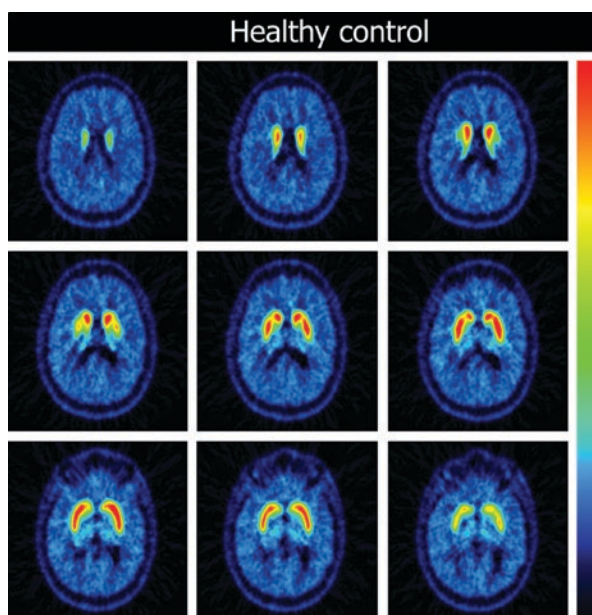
Transversal SPECT images obtained 3 h after i.v. injection of [ $^{123}\text{I}$ ]FP-CIT (radiotracer for the dopamine transporter) into a healthy female control subject. Intense symmetric and specific binding is visible in the caudate nucleus and putamen. The used colour scale represents a maximum intensity scale. This study has been acquired on a brain-dedicated SPECT system (InSPira)
